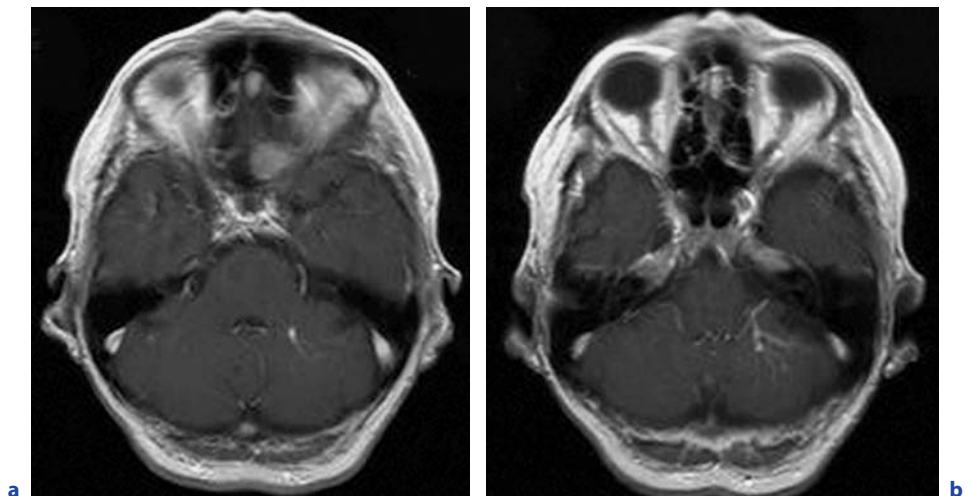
Axial contrast-enhanced T1-weighted magnetic resonance imaging with a developmental venous anomaly located in the left cerebellar hemisphere. Again, the transparenchymal draining vein is the most striking sign. In (b), the Medusa head is clearly visible. There is no need for an additional digital subtraction angiography
